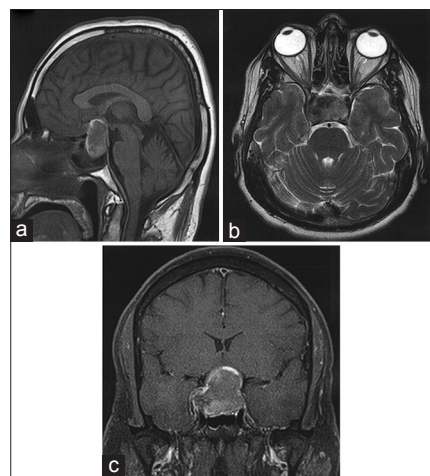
Preoperative sagittal T1 (a), axial T2 (b) and contrasted coronal T1 (c) MR images demonstrating large pituitary adenoma apoplexy with extension to the suprasellar region and compressing the medial wall of the right cavernous sinus
